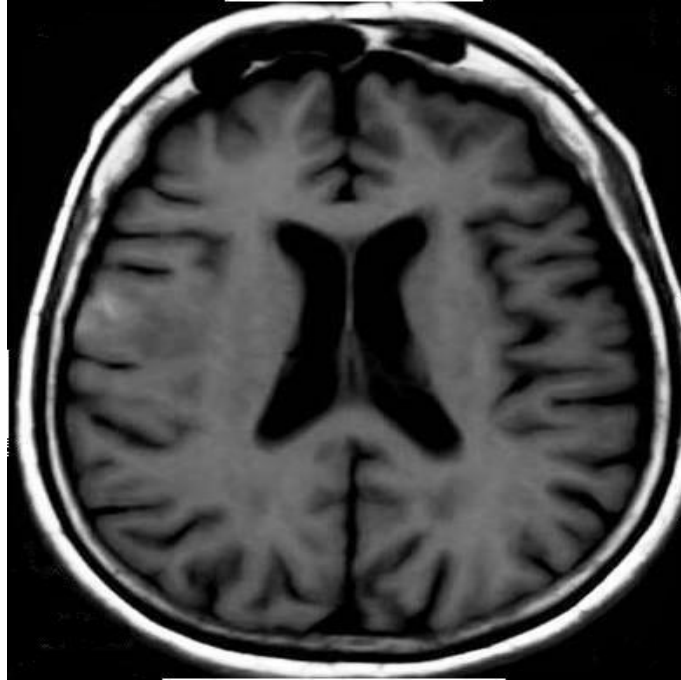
T1-weighted magnetic resonance image of the brain shows cerebral atrophy and decreased signal intensity and edema on the right frontal operculum. There are also areas of hyperintensity in the lesion, indicating a hemorrhagic infarction.
